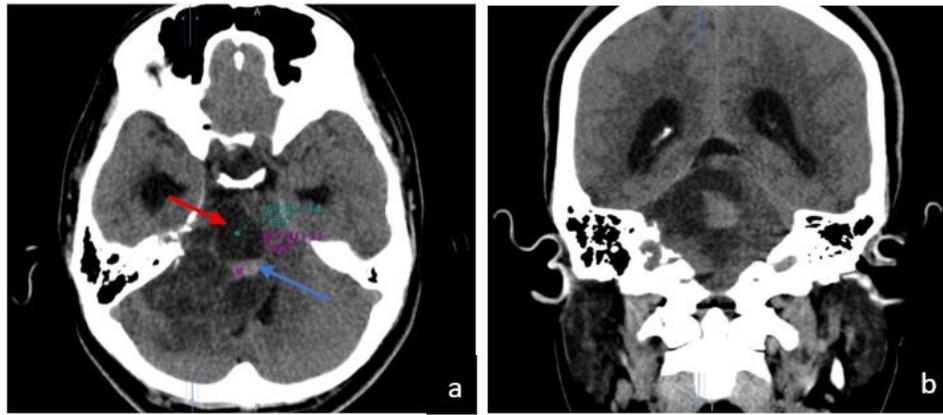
(a and b) Non-contrast head CT scans in axial and coronal sections show a hypodense lesion (HU 10.6 ± 4.8 , blue arrow) that appears inhomogeneous, with ill-defined margins and irregular borders, accompanied by calcification (HU 47.7 ± 3.7 , red arrow). The lesion is located in the right cerebellar region and the right skull base.
